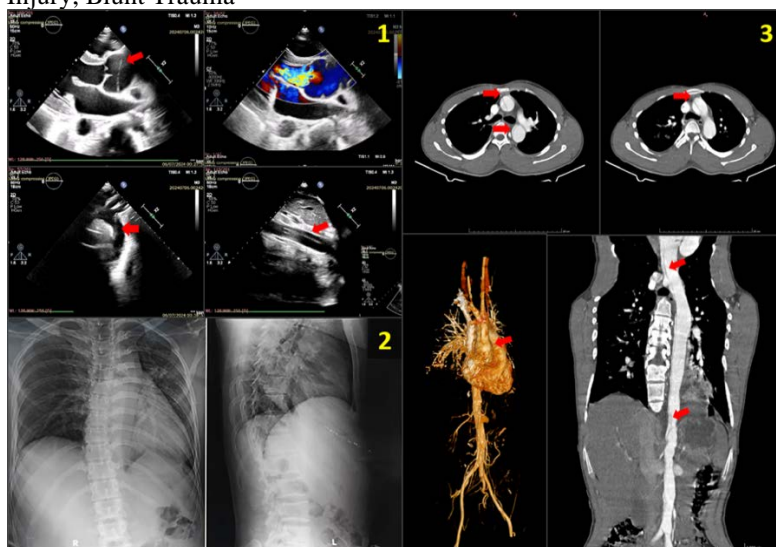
Echocardiography showed aortic dilatation with severe AR and flap at aorta ascenden, aortic arch and abdominal aorta (1). Chest X-Ray showed scoliosis with dilatation of aorta and cardiomegaly LV (2). CTA
